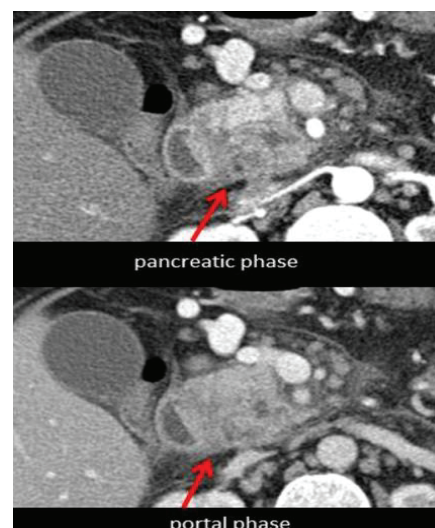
CT images - Para duodenal pancreatitis
